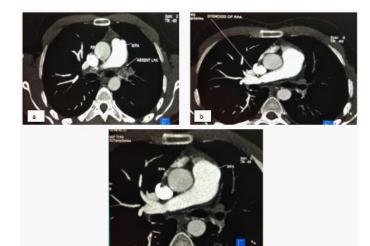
CT Pulmonary Angiography (CTPA) axial images at the level of pulmonary bifurcation revealing absence of LPA (arrow in a). RPA is seen and is normal at origin with a stenosis just distal to its origin (b and c).
